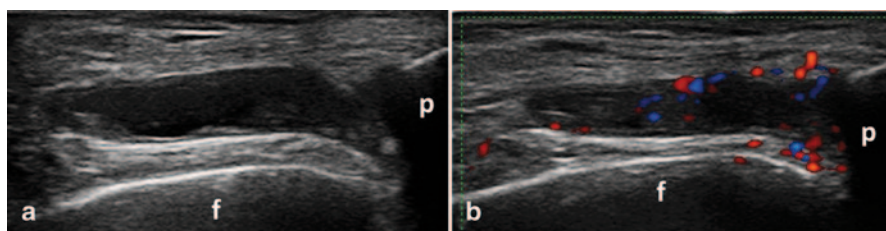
Transverse view over the parapatellar recess of the knee showing B-mode synovitis (a) with Doppler signal (b) synovitis; *f* femur, *p* patella
